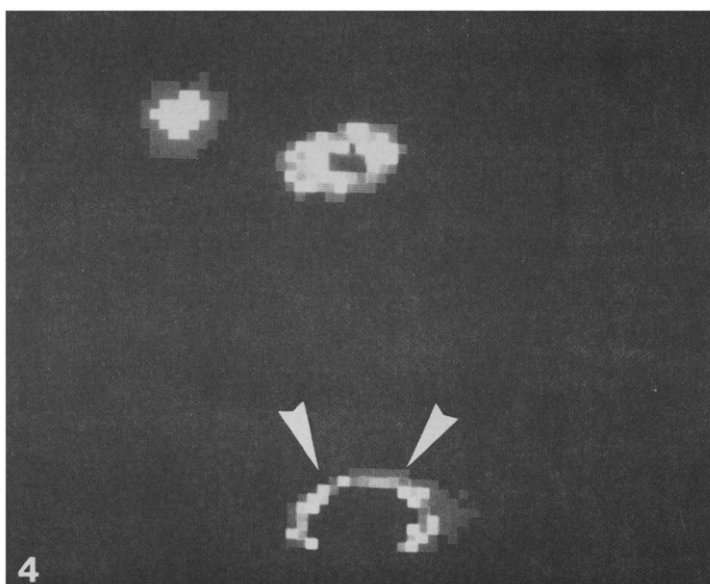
Axillary lymphoscintigraphy 4 hr after injection of 400 μ Ci of ^{99m}Tc sulphur microcolloid.
